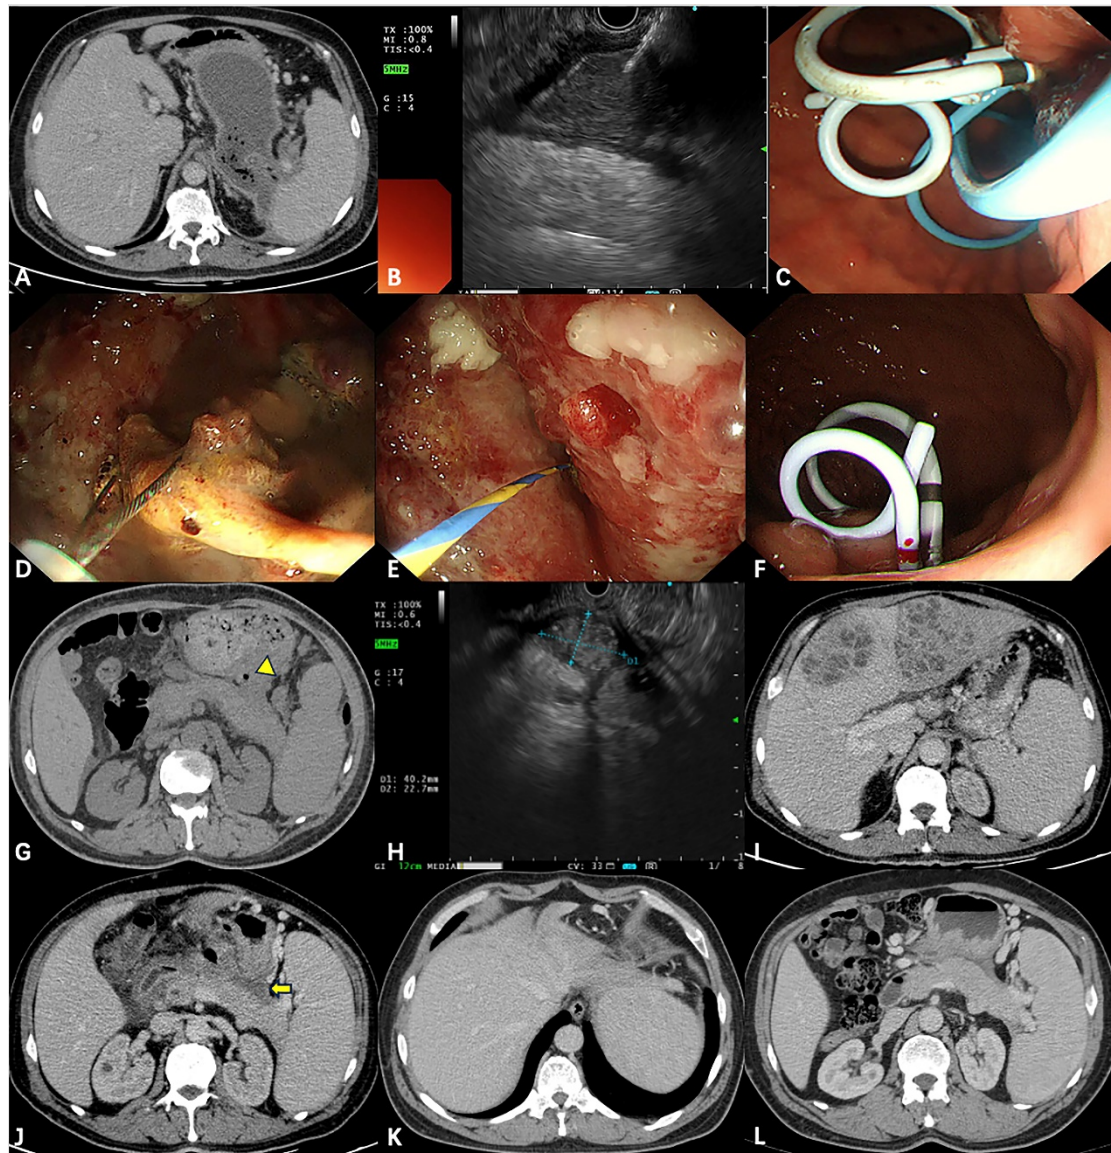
A. Computed tomography (CT) showing a walled-off pancreatic necrosis with air bubbles inside. B to E. Endoscopic ultrasound guided transgastric drainage followed by direct endoscopic necrosectomy. F. Endoscopic view showing 2 transmural indwelling stents at discharge. G and H. Follow-up CT (arrowhead) and endoscopic ultrasound 1 month after discharge showing residual pancreatic fluid collection (PFC). I and J. CT scan at the onset of fever 1 year later showing hepatic
